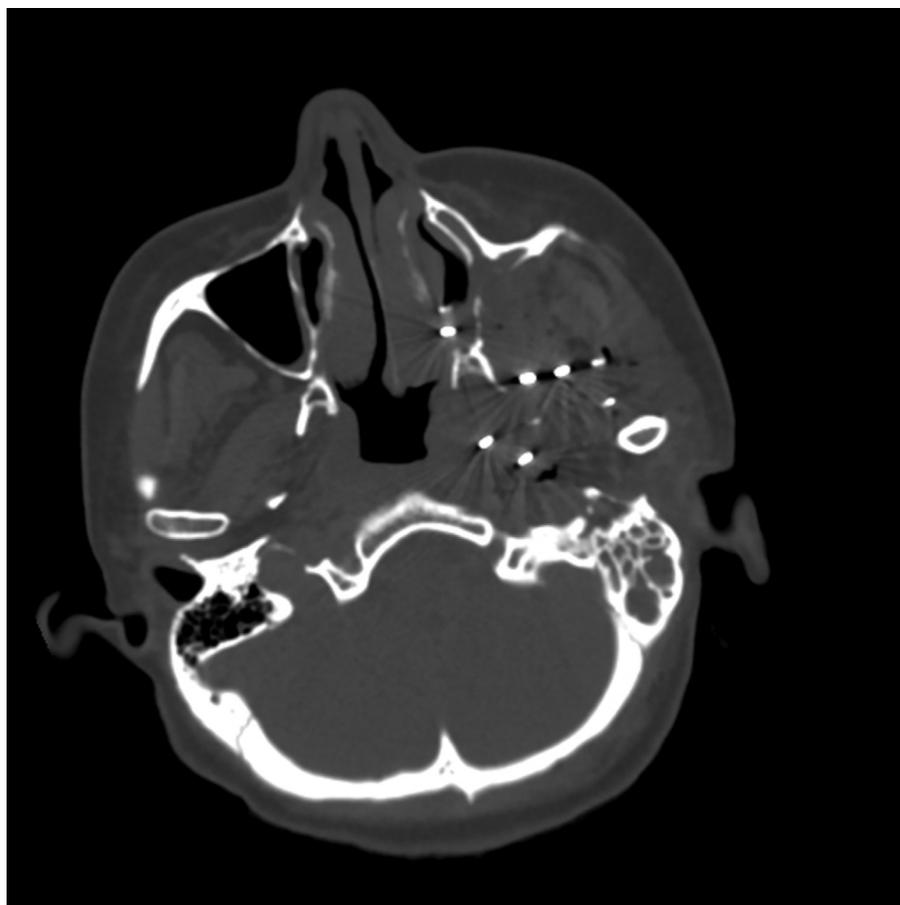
Computed tomogram immediately after implantation.
